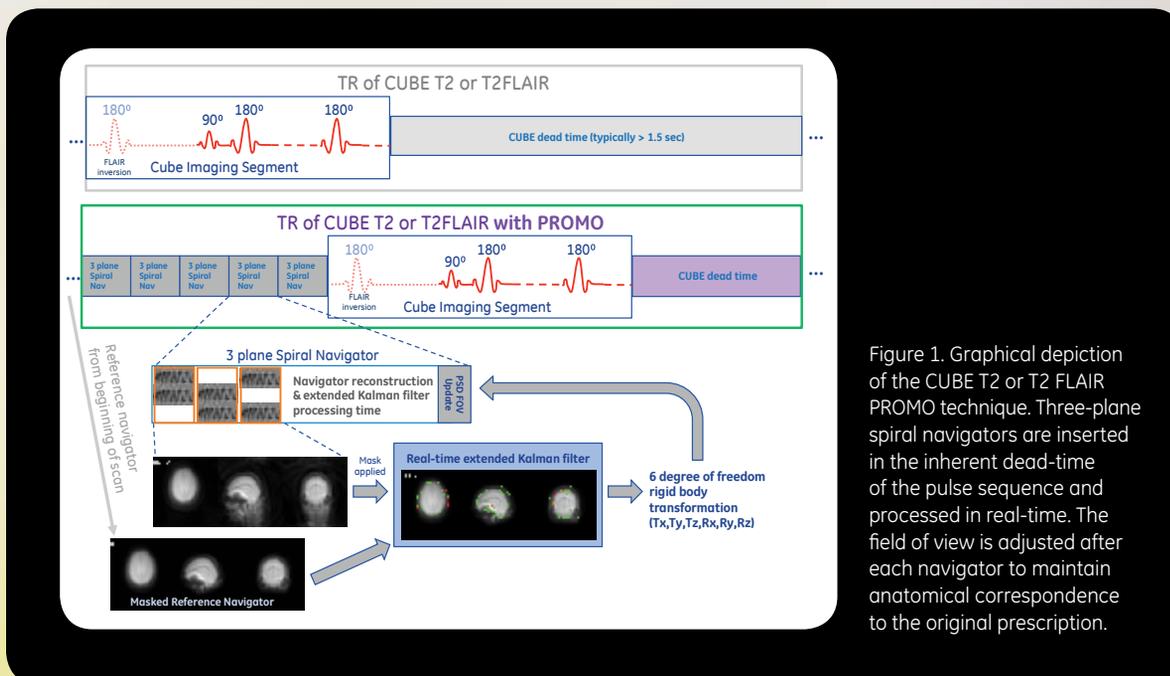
Graphical depiction of the CUBE T2 or T2 FLAIR PROMO technique. Three-plane spiral navigators are inserted in the inherent dead-time of the pulse sequence and processed in real-time. The field of view is adjusted after each navigator to maintain anatomical correspondence to the original prescription.
